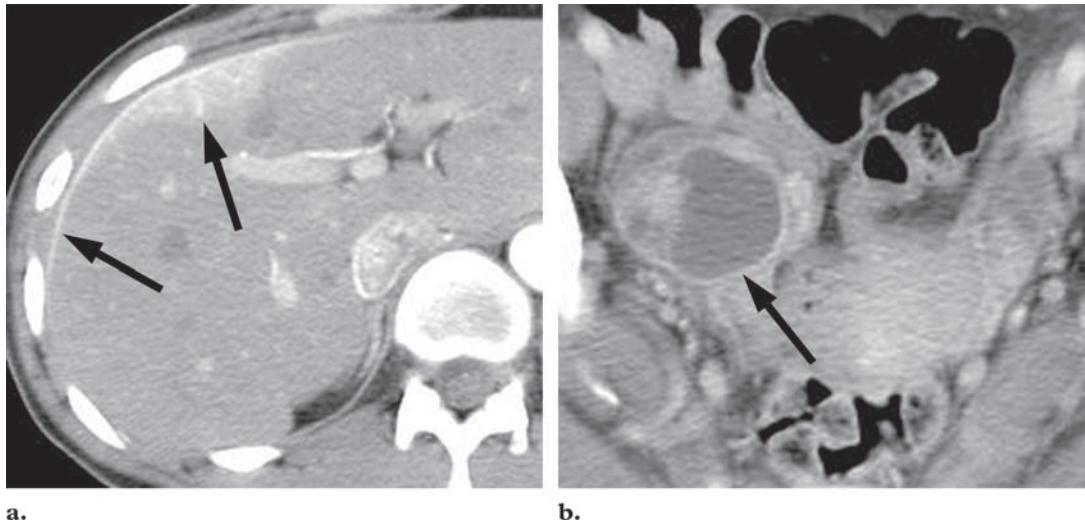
Fitz-Hugh–Curtis syndrome in a 33-year-old woman with right upper quadrant pain. (a) Contrast-enhanced arterial phase CT scan shows enhancement of the liver capsule and of the subcapsular portion of the liver (arrows). (b) Portal venous phase CT scan of the pelvis shows an ovoid hypodense mass with wall enhancement (arrow) at the right adnexa, a finding that is consistent with a tubo-ovarian abscess. The findings in both a and b are suggestive of Fitz-Hugh–Curtis syndrome.
